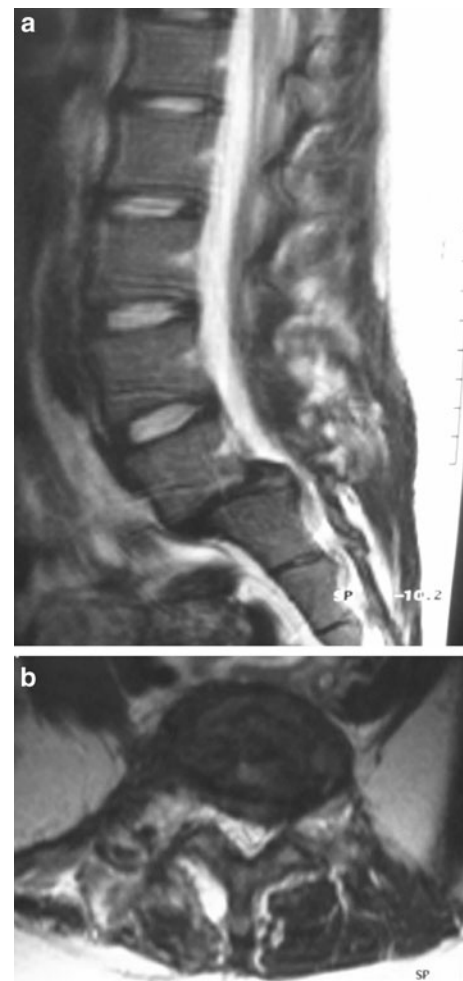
Sagittal (a) and axial (b) T2-weighted magnetic resonance imaging (MRI) showing disruption of the L5–S1 intervertebral disc
